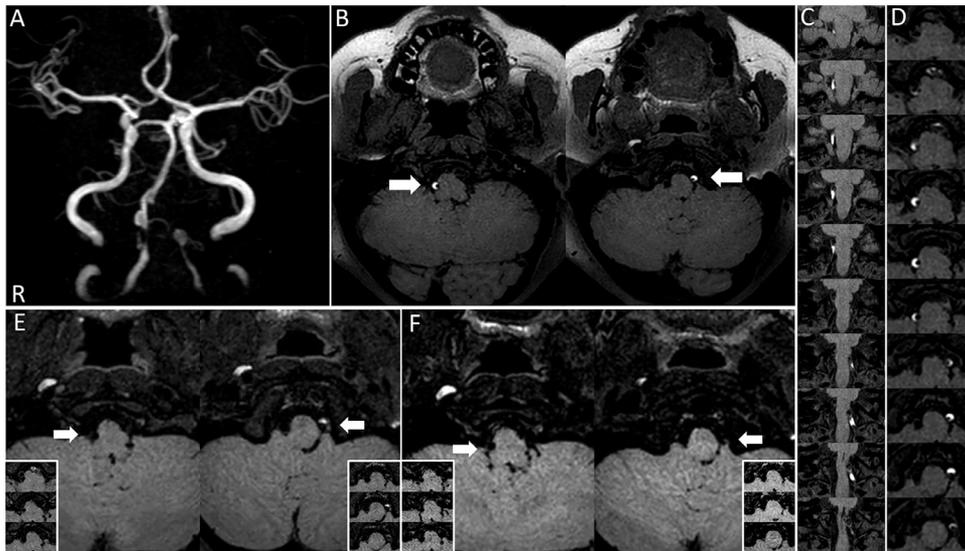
Temporal changes in the brain magnetic resonance imaging (MRI) findings.
